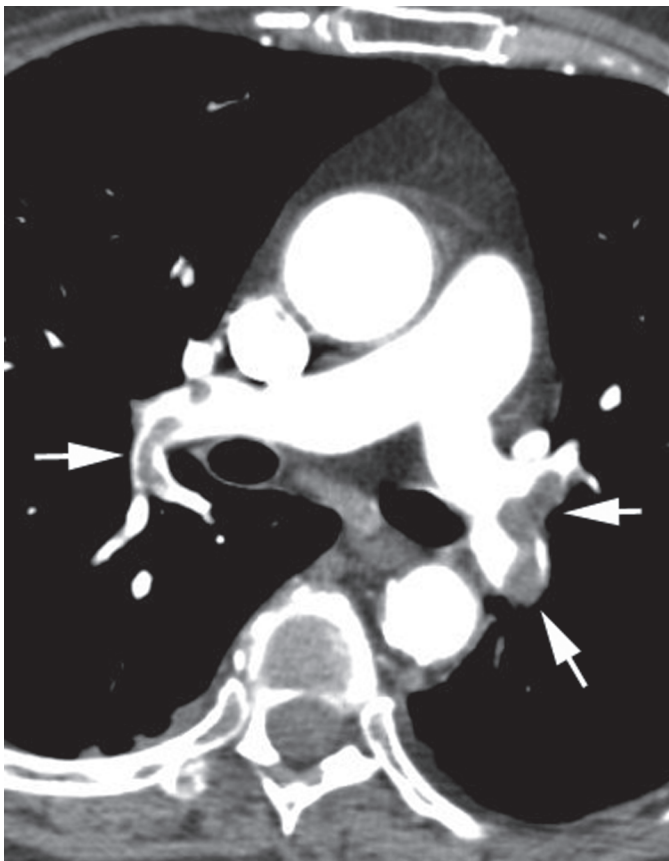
Acute pulmonary embolism. Contrast-enhanced axial computed tomography reveals low-attenuation emboli in the right and left pulmonary arteries (arrows).
